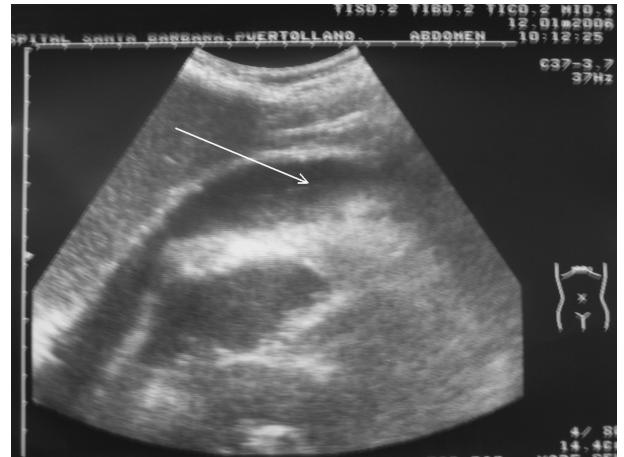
Bedside ultrasound performed by Emergency Department personnel: Pericardial effusion compressing right cavities to point of collapse (arrow).
